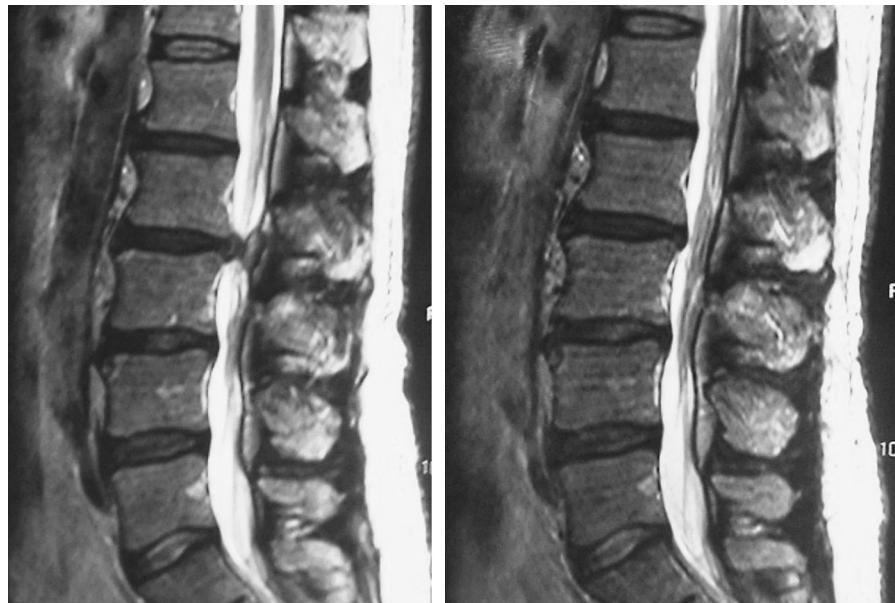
(Left) Posterior epidural migrated lumbar disc fragments were observed at L2–L3 on sagittal T2-weighted magnetic resonance imaging (MRI) at the first visit. (Right) Spontaneous regression of the posterior epidural migrated lumbar disc fragments was revealed on sagittal T2-weighted MRI at the final follow-up.
